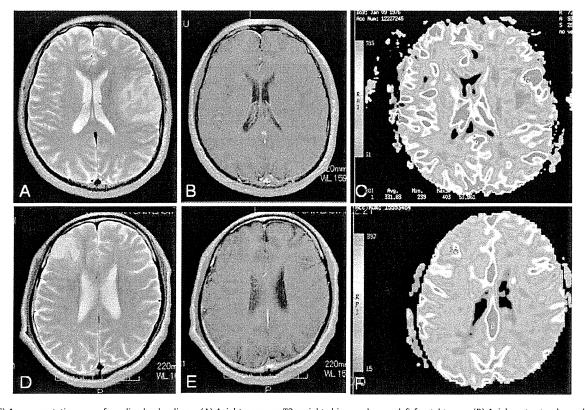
(A-C) A representative case of an oligodendroglioma. (A) Axial transverse T2-weighted image shows a left frontal tumor. (B) Axial contrast-enhanced transverse T1-weighted image shows the tumor with faint partial enhancement. (C) The rCBV map shows that the rCBVmax value of the tumor is 5.12. (D-F) A representative case of an anaplastic oligodendroglioma. (D) Axial transverse T2-weighted image shows a right frontal tumor. (E) Axial contrast-enhanced transverse T1-weighted image shows the tumor without enhancement. (F) The rCBV map shows that the rCBVmax value of the tumor is 6.23.
